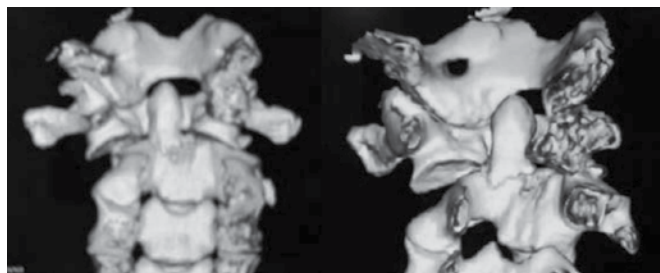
Computed tomography with 3D reconstruction evidencing Type II odontoid fracture.
